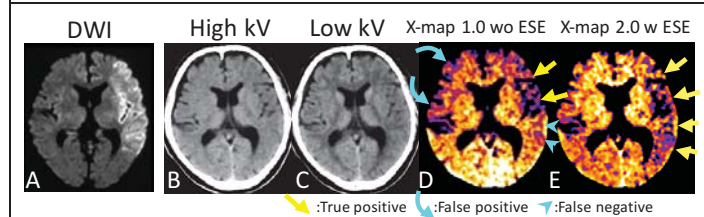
NE-DE-CT was taken 53 min after the symptom onset; DWI 40 min after CT. The color images were generated using “fire” in ImageJ.
